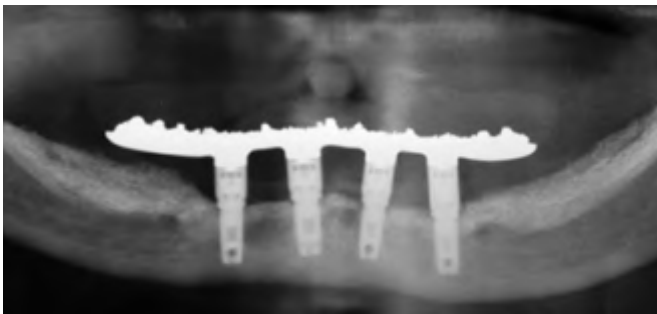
Panoramic radiograph of the patient in Figure 11.4. The radiograph demonstrated minimal bone loss around the implants. The patient originally presented to the authors after she had been grafted with hydroxyapatite granules in the mandible approximately 7 years previously. The graft was not successful in improving the patient's ability to wear a mandibular complete denture. The granules were removed in the anterior region prior to placement of the endosseous implants.
